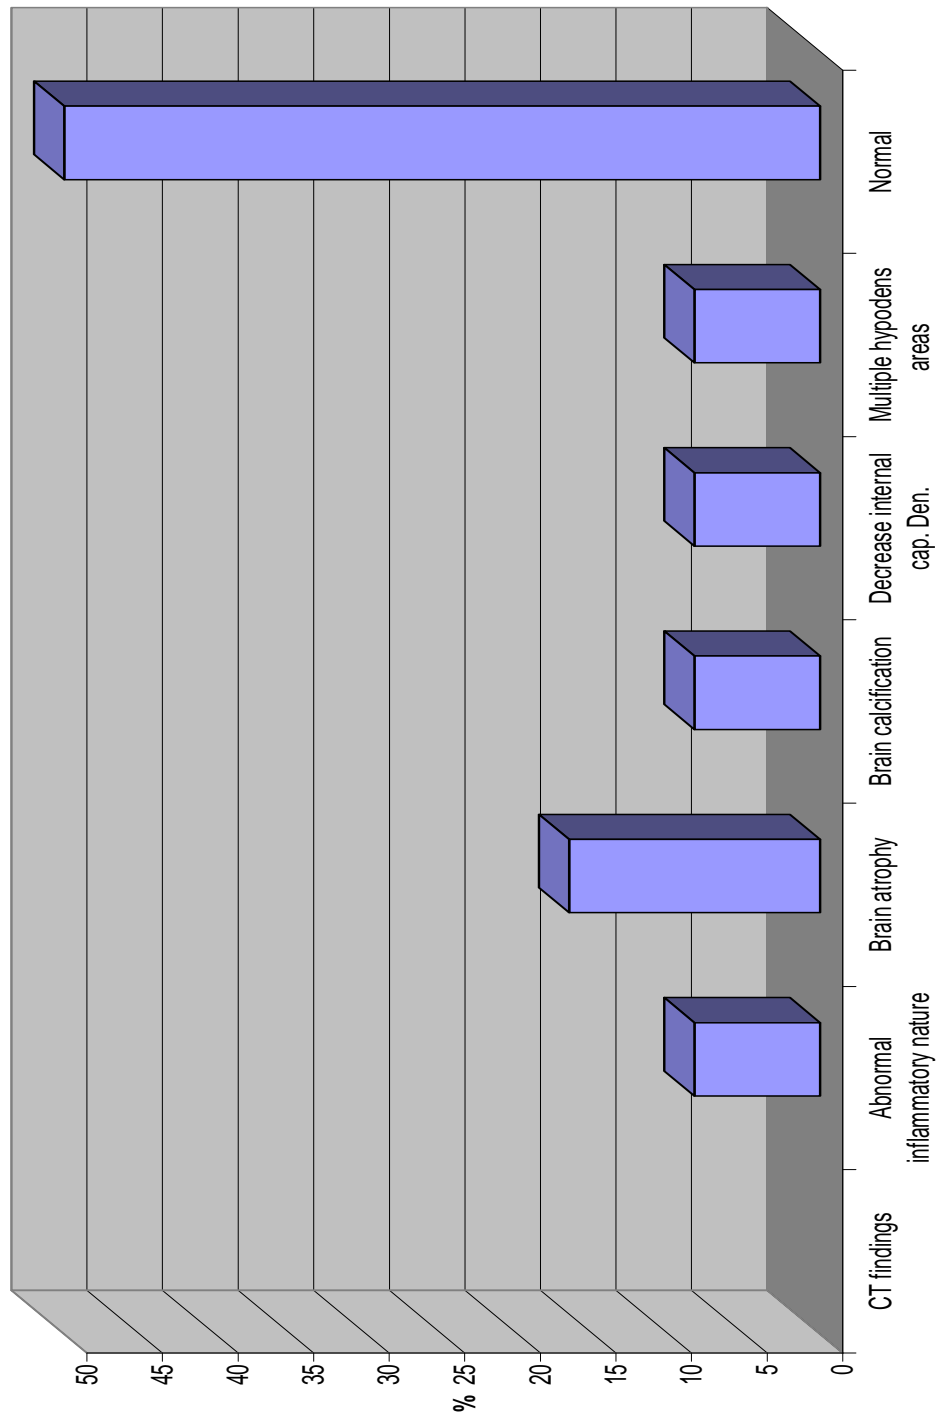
shows CT findings
